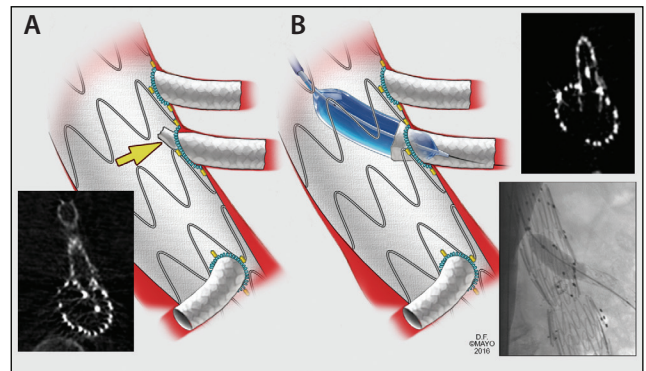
CBCT reveals compression of the SMA stent (A), which tends to occur during advancement of the distal bifurcated device or one of the iliac limbs. This was immediately revised by balloon inflation (B), avoiding the dreaded complication of early SMA thrombosis. With permission of Mayo Clinic Foundation.
